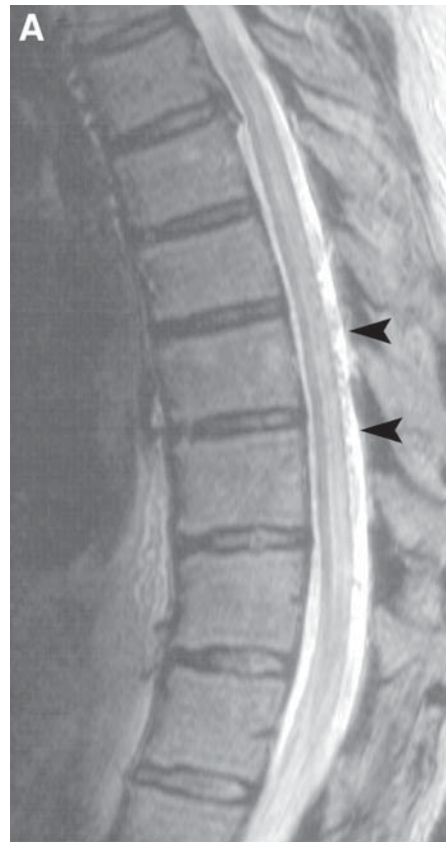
Dural arteriovenous fistula. A type I AVM is identified on the sagittal T2-weighted images (A, B). Abnormal serpiginous vessels are seen dorsal to the distal spinal cord and in the distal aspect of the spinal canal.
